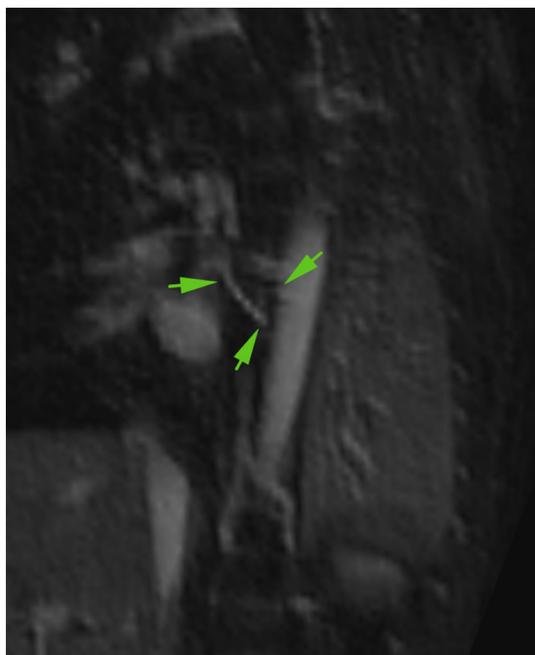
3-dimensional magnetic resonance imaging (MRI) shows major pulmonary collateral arteries coursing from the thoracic aorta toward the not-visualized pulmonary trunk. Arrows highlight the anomalous intraesophageal collateral artery appreciated on autopsy.
